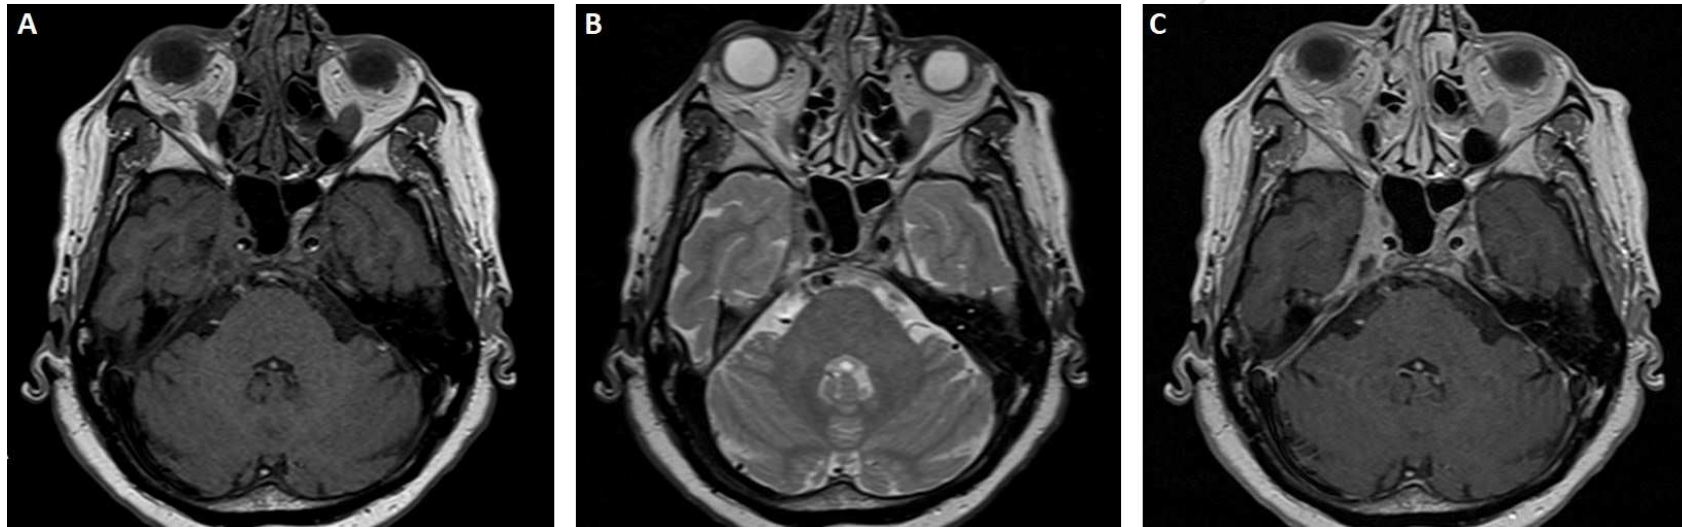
MRI of the patient. Axial view of sella showed a lesion in the right parasellar which occupied right cavernous sinus on T1-weighted (A) and T2-weighted (B) images. Intravenous gadolinium administration demonstrated a lesion with homogeneous enhancement on the T1-weighted image (C).
